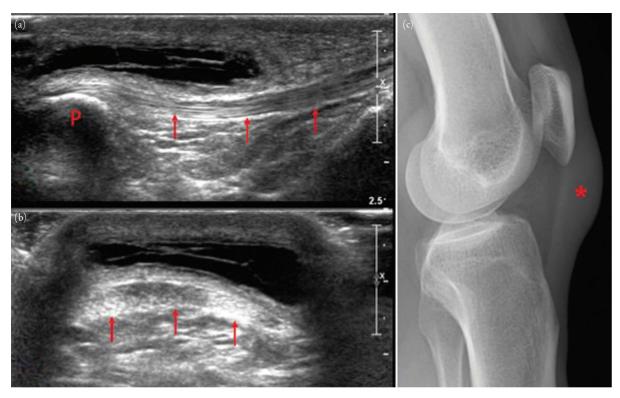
Prepatellar bursitis. Panels (a) and (b), respectively, show grayscale sonographic images in longitudinal and transverse plane of another patient with prepatellar bursitis. A septated cystic appearing soft tissue mass anterior to the proximal patellar tendon (arrows) extends from the inferior pole of the patella (P). Knee radiograph (Panel c) shows focal soft tissue prominence in the expected region of the prepatellar bursa (*).
